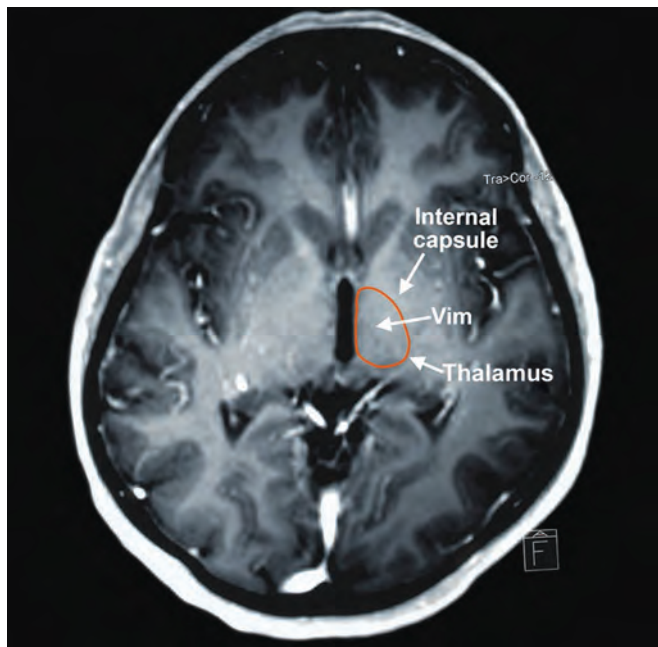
MRI at the level of AC-PC showing different thalamic nuclei including Vim
